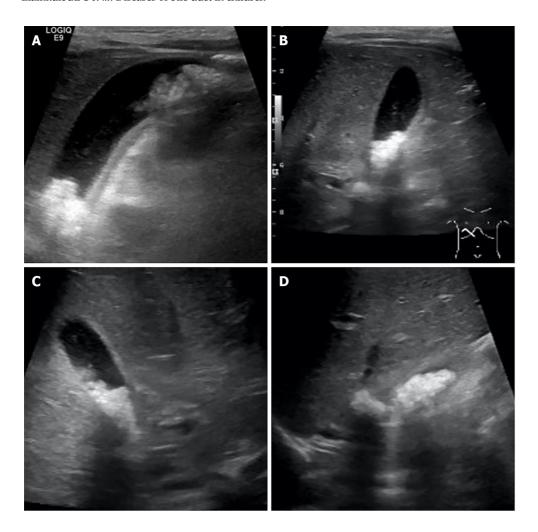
A 3-year-old girl was diagnosed with tetralogy of Fallot and brain abscess. She was admitted for intravenous antibiotic therapy, including ceftriaxone 100 mg/kg/d and metronidazole 30 mg/kg/d for 6 wk. After 3 wk of ceftriaxone administration, she experienced intermittent colicky pain in her right upper abdomen and ultrasonography showed an enlarged gallbladder with multiple gallstones in the posterior dependent part extending to the gallbladder neck. A: Multiple gallstones; B: Enlarged gallbladder measuring 6.3 cm in length, 1.5 mm gallbladder wall, and no pericholecystic fluid; C: Enlarged gallbladder with multiple gallstones in the posterior dependent part extending to gallbladder neck; D: Multiple gallstones.
